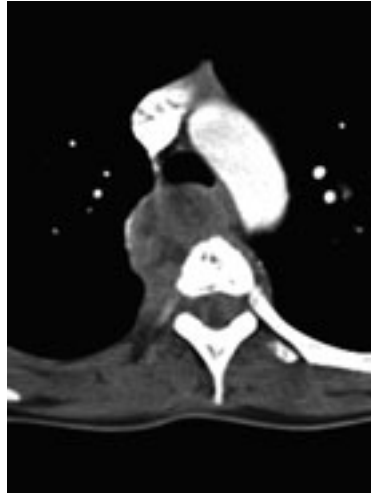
CT of the thoracic spine (axial). Large right anterolateral soft tissue tumor with impression of the trachea. Lesion extends to the aortic arch.
